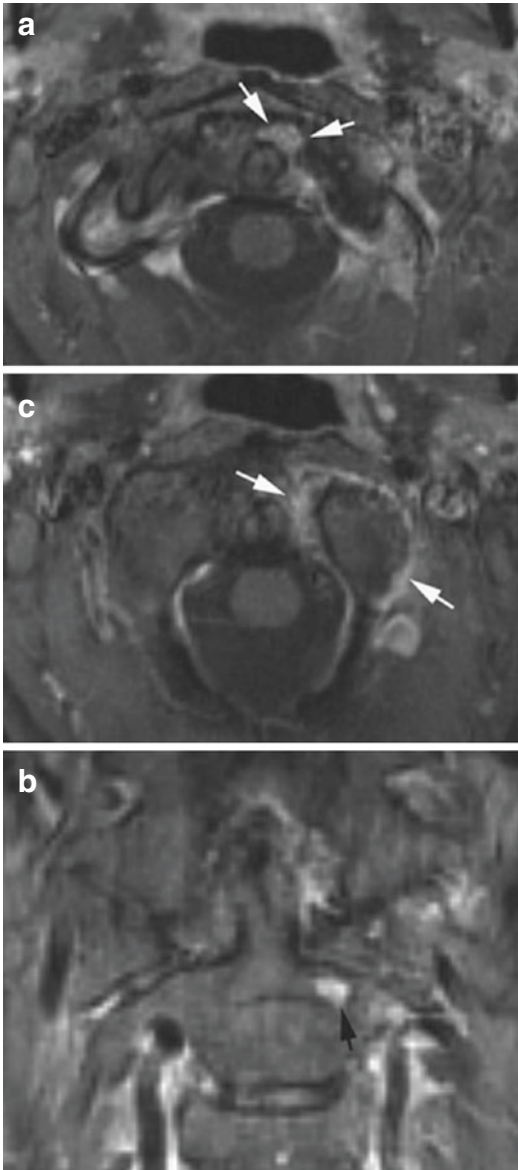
A 42-year-old woman with RA and neck pain. Radiographs (not shown) were normal; post-contrast axial (a and b) and coronal (c) T1-weighted, fat-saturated images on the dens demonstrate enhancing pannus (white arrows) and subchondral enhancement (black arrow), both without erosions, indicating early, or pre-erosive, disease, expected to be occult on both radiographs and CT [6]
